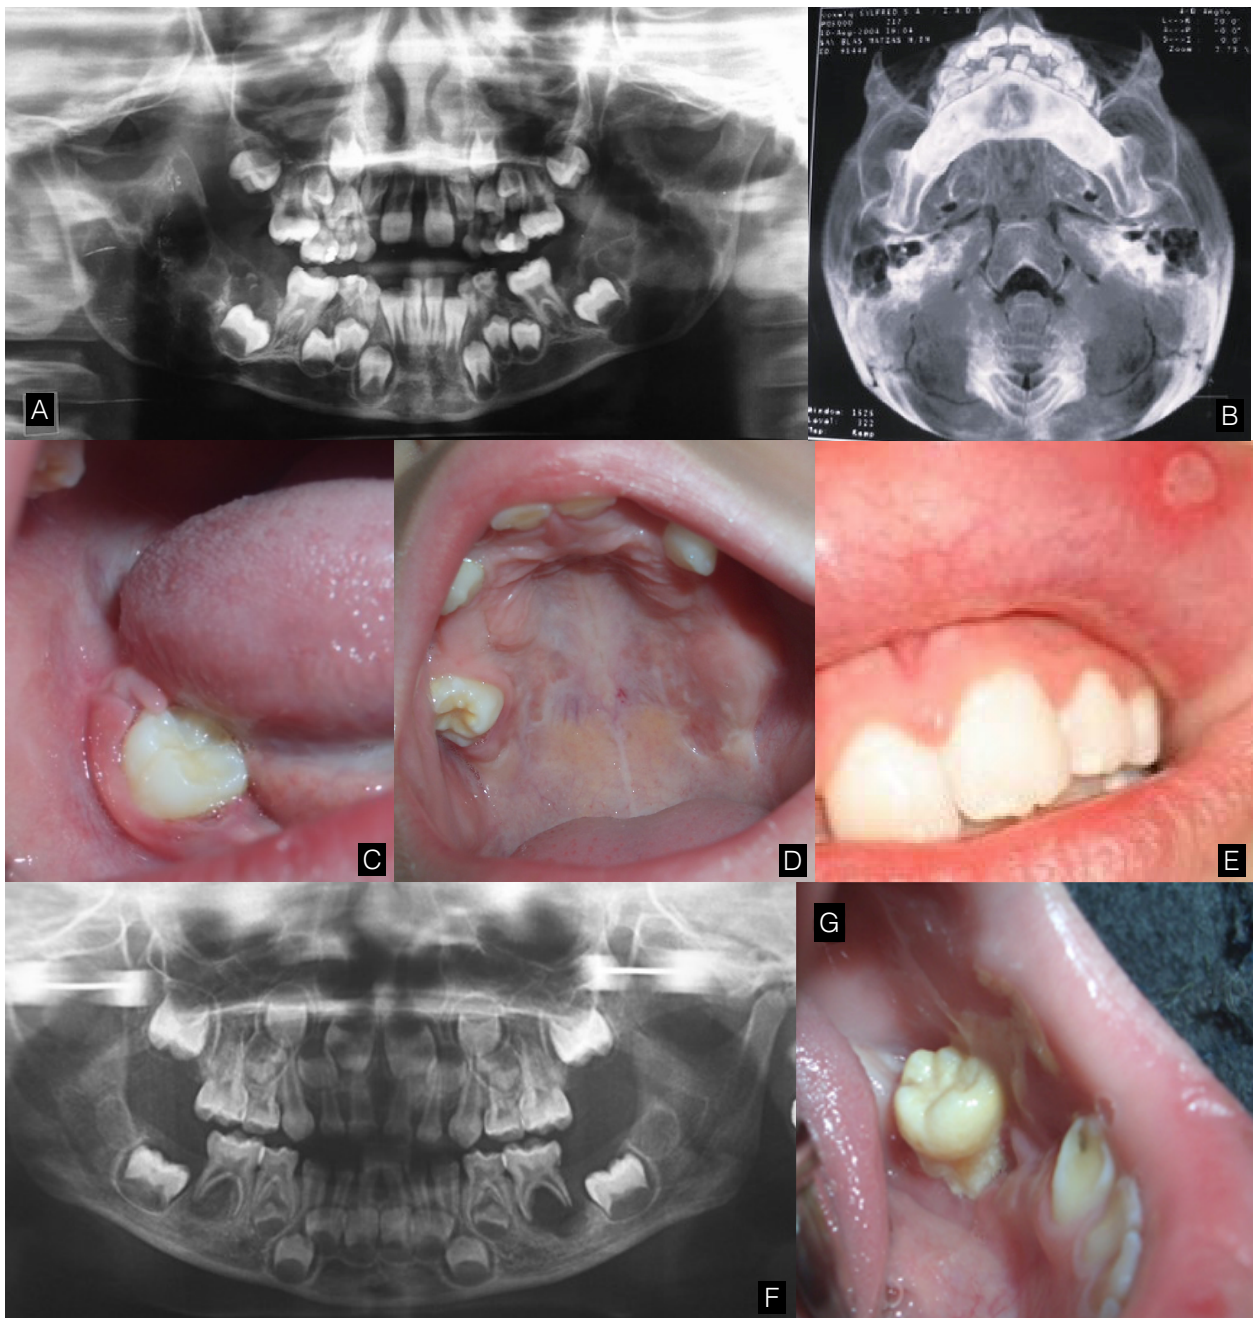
HCL oral lesions. A) Bone lesions. Panoramic radiograph showing radiolucent areas compatible with osteolytic lesions on both jaws. B) CT scan: osteolysis visible in the mental area. Lesions on mucosa: C) Pericoronitis of tooth 4.6; D) Rash and erosion on palate, and E) Persistent erosive lesion on upper lip mucosa. F) Bone-mucosal lesions. Panoramic radiograph with radiolucent zones compatible with osteolytic lesions of the alveolar bone surrounding teeth 7.5 and 8.5. G) Photograph of tooth 7.5 without bone support, showing exposed root portion.
